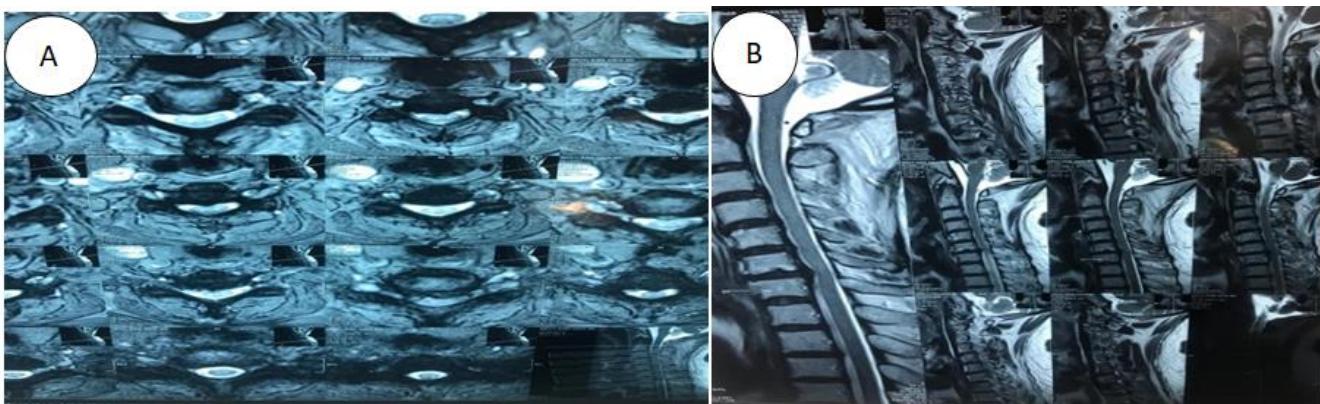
(A,B): MRI of the cervical spine showing disc prolapse.
